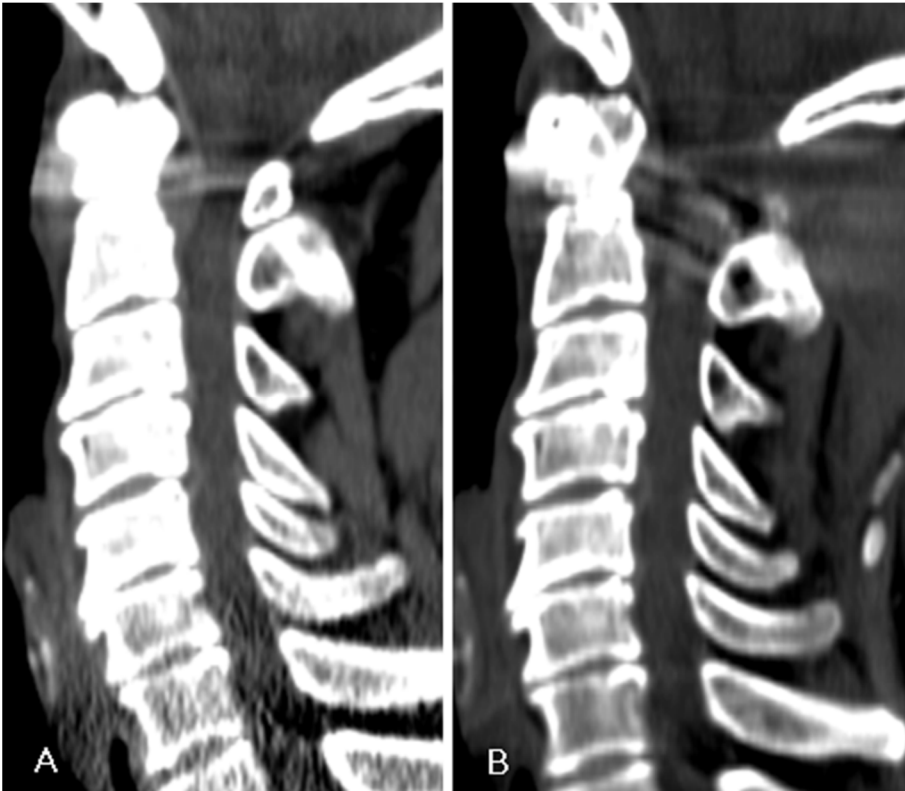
A 63-year-old male with old dens fracture. Retro-odontoid high attenuated mass representing pseudotumor is well-delineated in the preoperative CT (A). 6 months after C1-2 fixation, pseudotumor regression is noted in postoperative CT (B).
